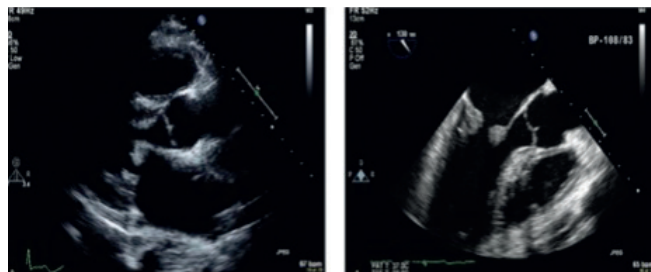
Echocardiographic images of a case of Libman-Sacks Endocarditis in a SLE patient demonstrating a symmetrical mass-like structure on the tips of both leaflets of mitral valve extending to the body. [Reproduced from Al-Jehani et al,³⁹ under CC BY 4.0 licence]
